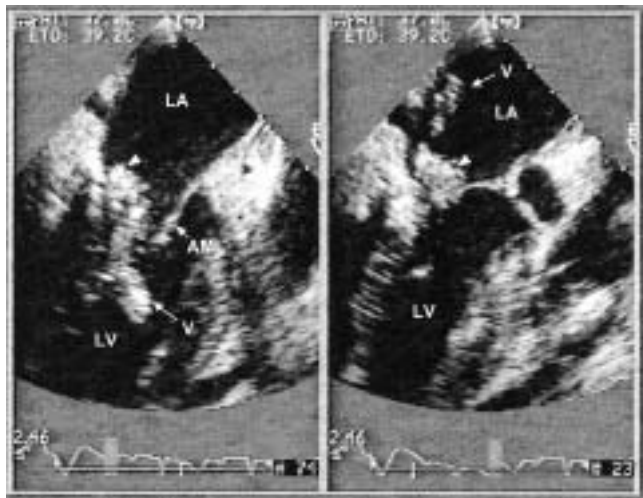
Transesophageal echocardiography. Example of a long vegetation, containing calcium-dense echoes, attached to the posterior part of the calcified mitral ring which takes on a 'puffed-up' appearance (arrowhead). (116° oblique plane; left: Diastole; right: Systole). AML: Anterior mitral leaflet; LA: Left atrium; LV: Left ventricle; V: Vegetation.
